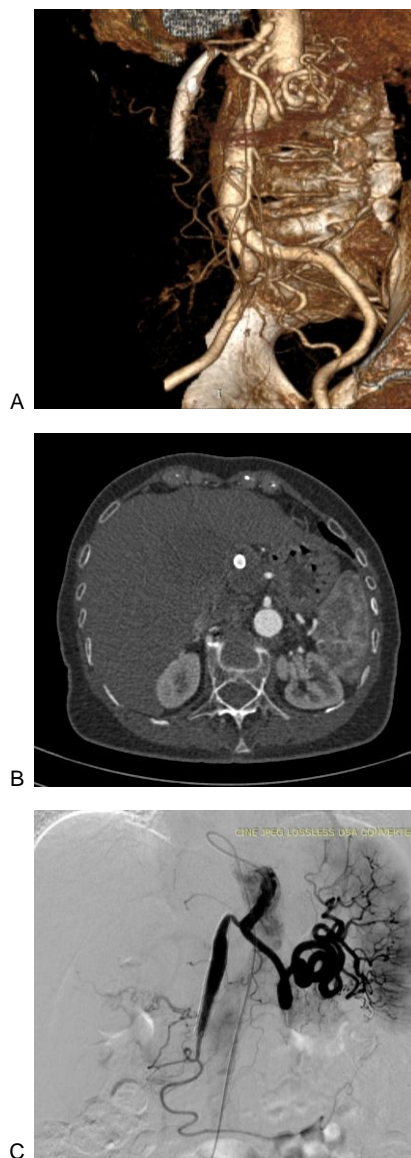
CT and angiographic findings post-treatment. A) and B) 3D VR angiography and axial contrast-enhanced CT 40 days post-treatment both shows good position of stents and patent CHA, complete thrombosis of the aneurysm; C) DSA three months after procedure performed via right femoral approach SIM 2 catheter used to cannulate celiac trunk, clearly confirms stents patency, no residual aneurysmal sac filling and good flow in hepatic and splenic arteries
